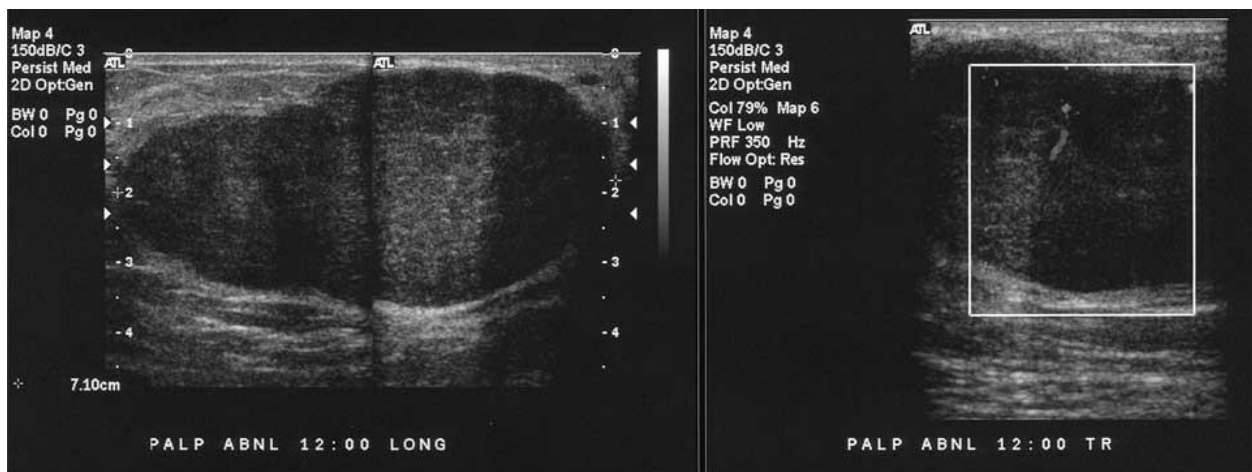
Typical ultrasound features of FA (Asim & Frank 2003).
